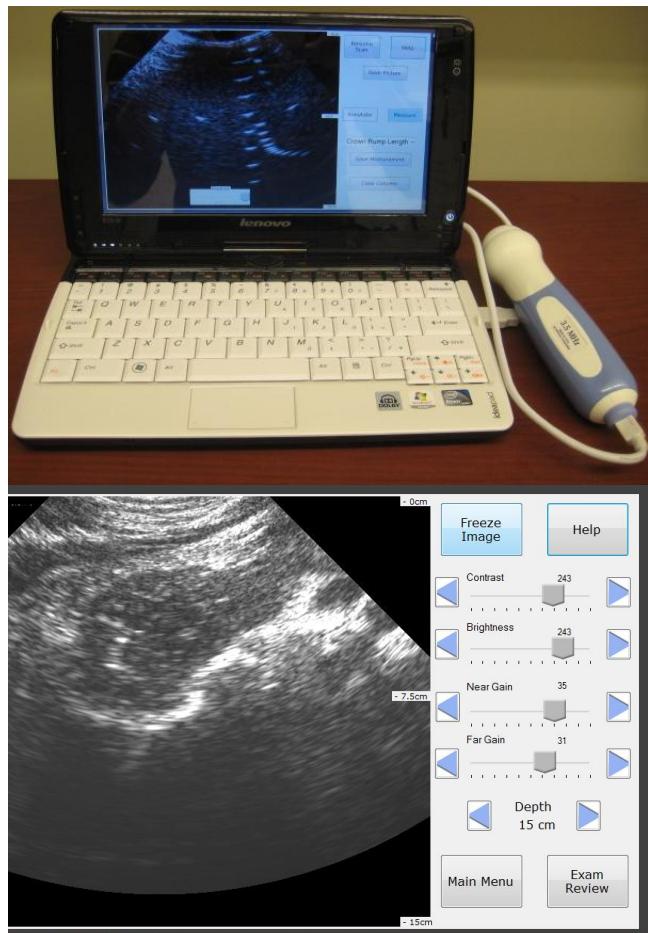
Prototype platform consisting of USB probe and netbook (above). Ultrasound scanning screen of the prototype simplified UI (below).
